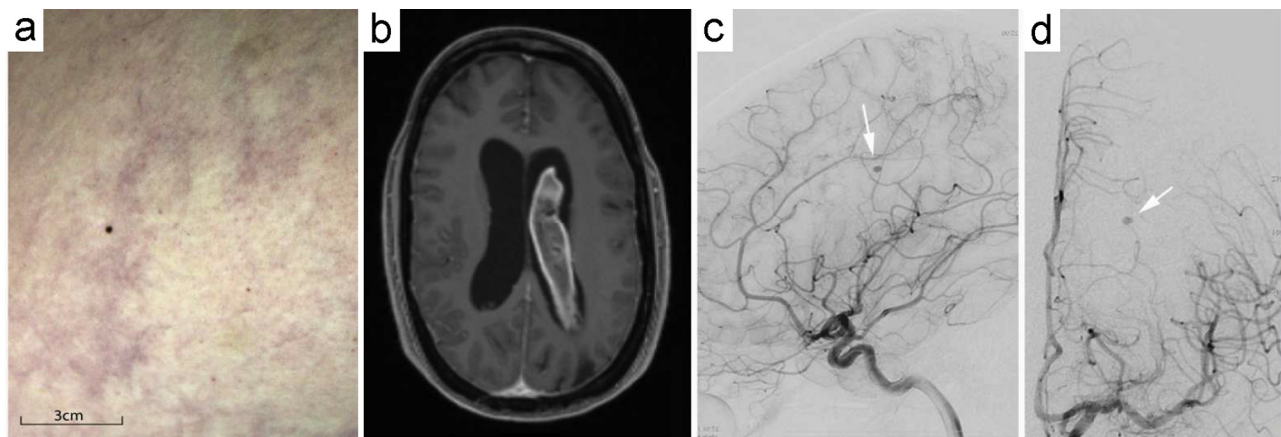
(a) Photograph of the patient's right lateral thigh demonstrating the characteristic *livedo racemosa* skin lesions which, when associated with cerebral ischaemic events, define Sneddon's syndrome. The patient had widespread lesions over the trunk, buttocks and limbs. (b) Axial T1-weighted cranial MRI showing three-day-old intraventricular haematoma in the right lateral ventricle. (c) Digital subtraction angiography demonstrating 6 mm, fusiform, distal lenticulostriate aneurysm (arrow) arising from a branch of the right middle cerebral artery. Note the diffuse, fine collateral vessels, some of which exhibit beading and corkscrewing. (d) Anterior view of digital subtraction angiogram demonstrating the paucity of flow to deep structures. The aneurysm is once again arrowed.
